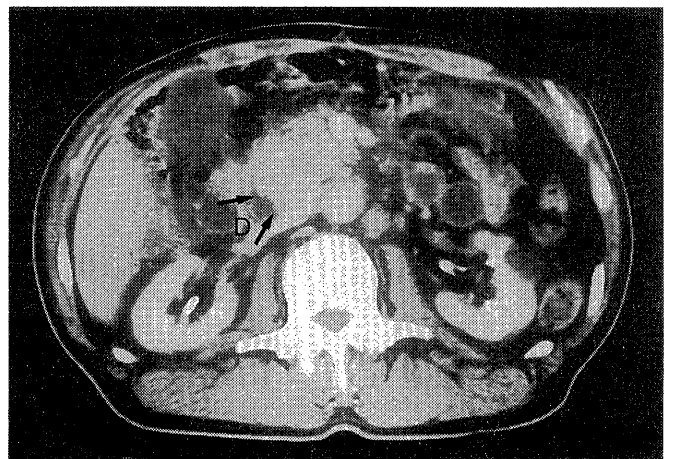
CT scan demonstrates a tumor of the ampullary region (arrows). D : second portion of the duodenum.
